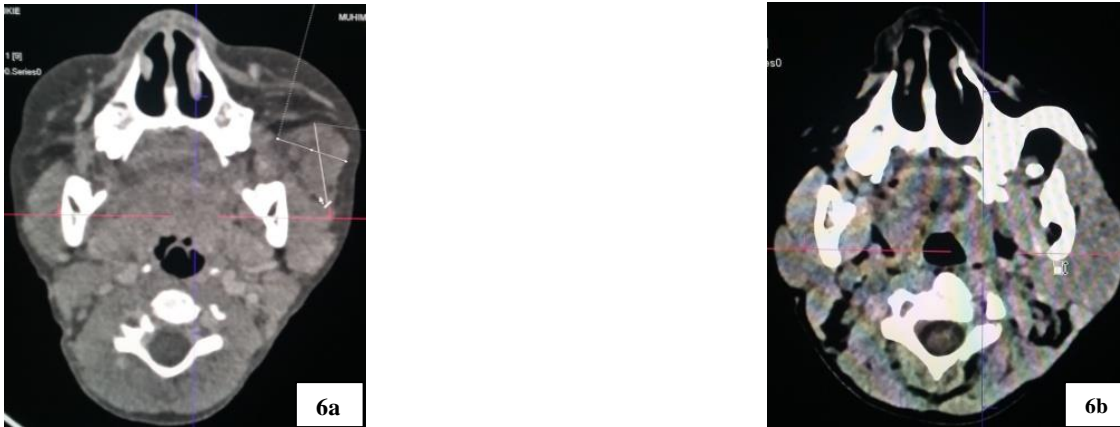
(a) Hemangioma on 8 year old child in the left cheek measured 3.10x2.74 cm by CT scan before sclerotherapy
